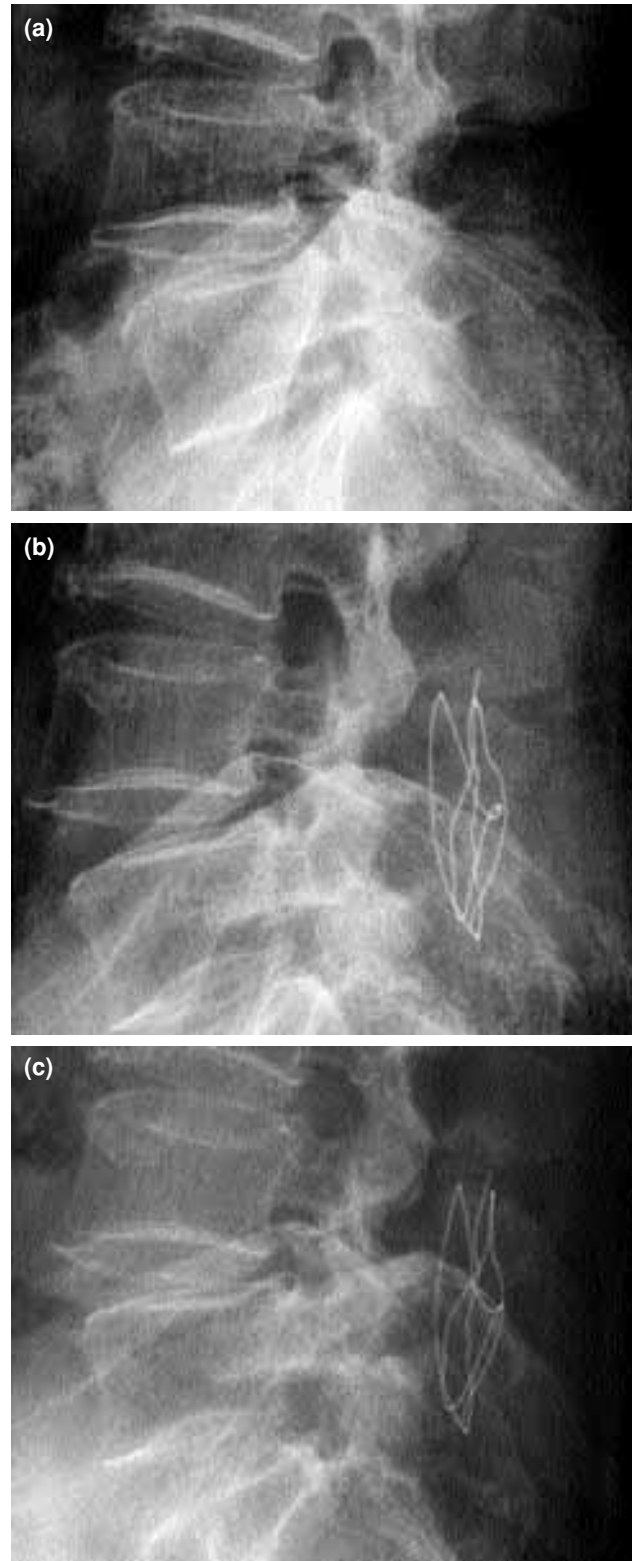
(a) A preoperative radiograph. (b) Immediate postoperative radiograph showing reduction and good coiling around the spinous process. (c) Fifteen months after surgery, a progressive slippage and some erosion to the upper spinous process were seen; however, the patient's complaint of low back pain improved regardless of this phenomenon.
